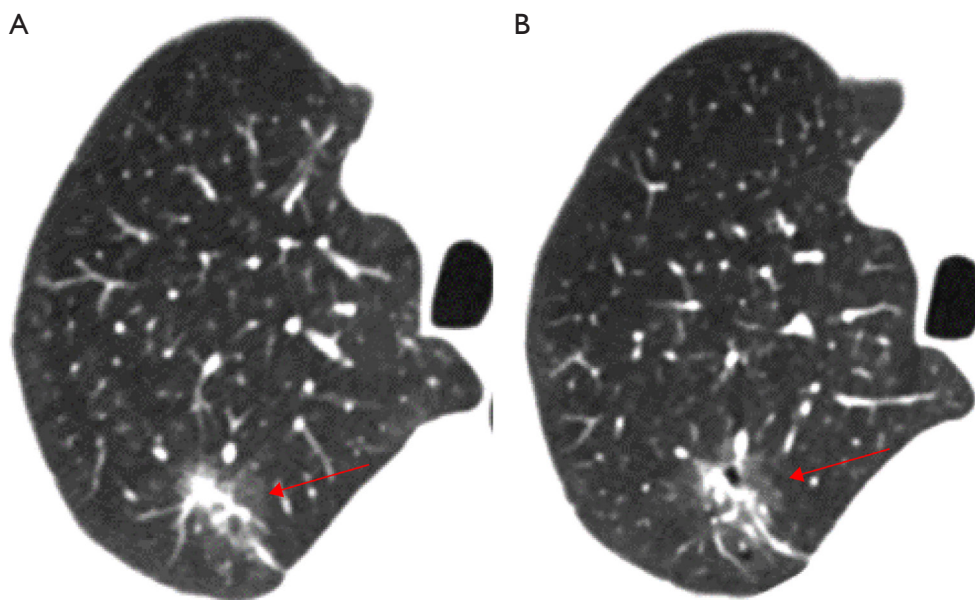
IAC. M, 59 y/o. (A,B) A mGGN in the right superior lobe (as indicated by the arrows); clear interface; 31 mm × 20 mm; solid component: 7 mm × 8 mm; CTR: 0.26; CT value: -502 ± 213.7 HU; uneven density; lobulation; tumor vascular sign (type IV); vacuole; pleural indentation (type b); no spicules or cavities. IAC, invasive adenocarcinoma; M, male; y/o, years old; mGGN, mixed ground-glass nodule; CTR, consolidation tumor ratio; CT, computed tomography; HU, Hounsfield unit.
